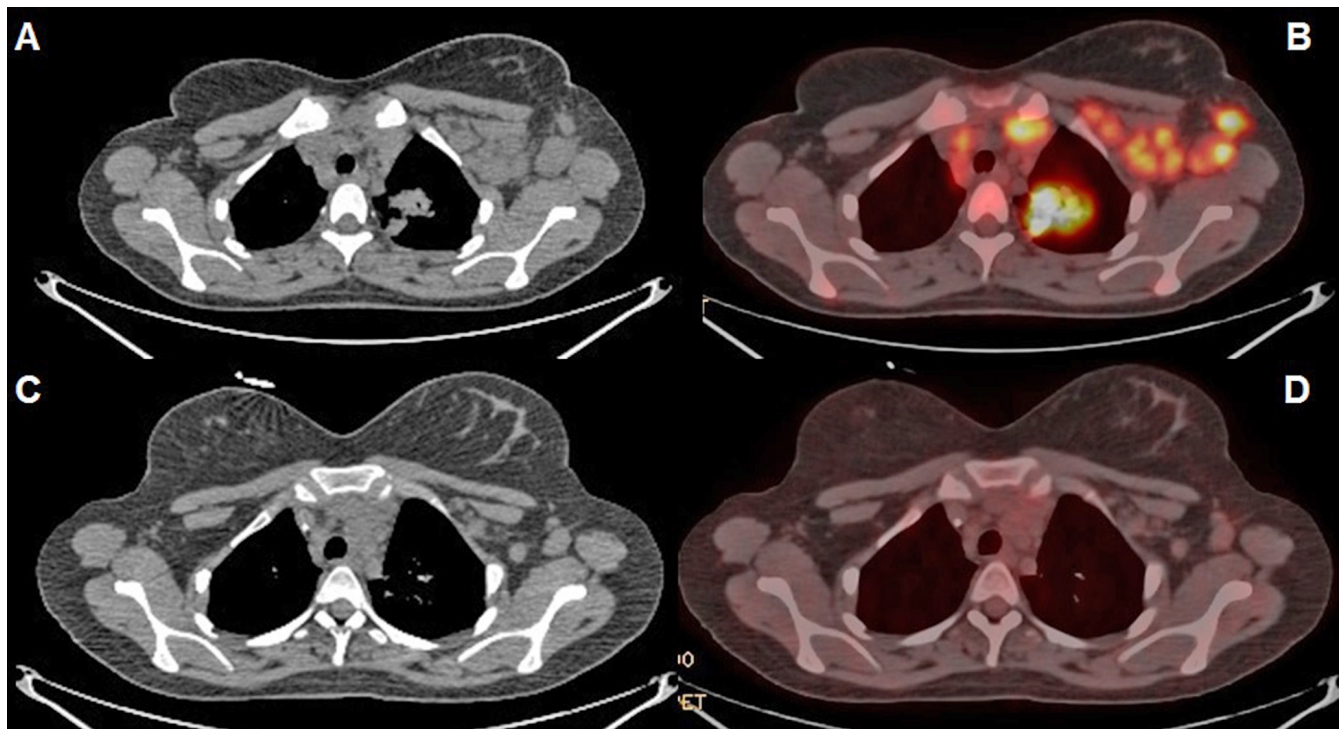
A 17-year-old female with classical NS type HL; axial CT and PET-CT (fusion) images performed before (A, B) and after OEPA treatment (C, D)
